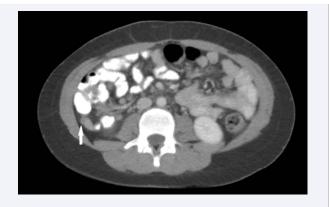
CT of the abdomen showing (white arrow) a dilated appendix with a distended lumen (10mm).
